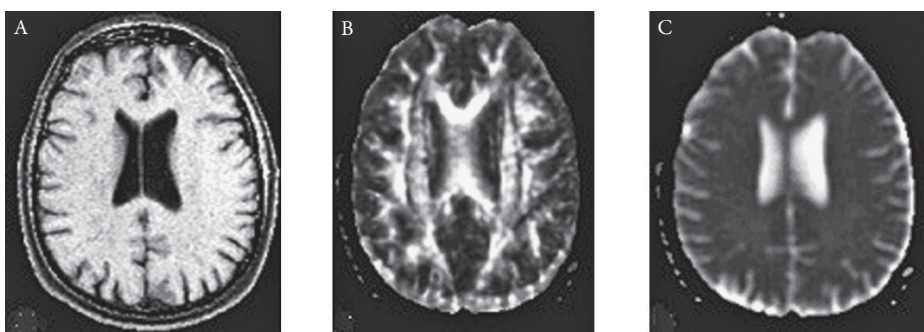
(A–C) Example of magnetization transfer magnetic resonance imaging (A) compared with fractional anisotropy (B) and mean diffusivity (C). (Adapted with permission from Schiavone F. *J Magn Reson Imag*. 2009;29:23–30.)
